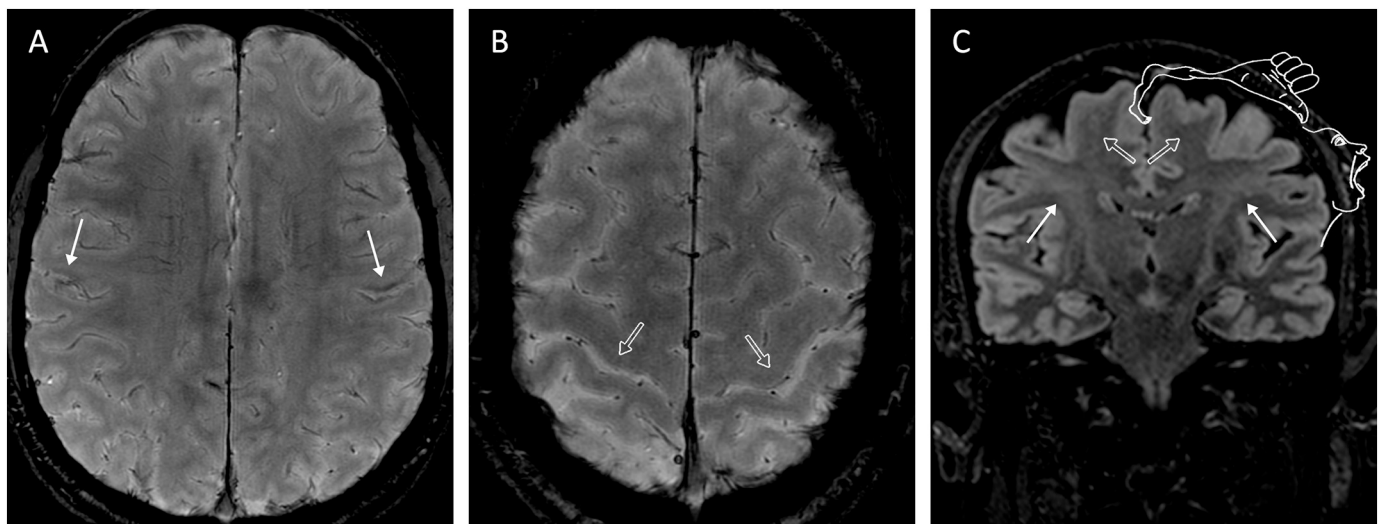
Axial T2*-weighted images of the primary motor cortex (A and B) and a coronal T2 FLAIR image at the level of the corticospinal tract (C) of an ALS patient with bulbar impairment. In both hemispheres, the deep layers of the orofacial region of the primary motor cortex appear hypointense (A, arrows) and the white matter in the location of the corticobulbar bundle is hyperintense in the T2 FLAIR image (C, arrows). On the contrary, the primary motor cortex corresponding to the functional areas of limbs (B, outlined arrows) are neither thin nor hypointense compared to the post-central cortex and the white matter in the location of the corticospinal tract is not hyperintense (C, outlined arrows). The representation of the motor homunculus in C has been modified from Penfield and Rasmussen, 1950.
